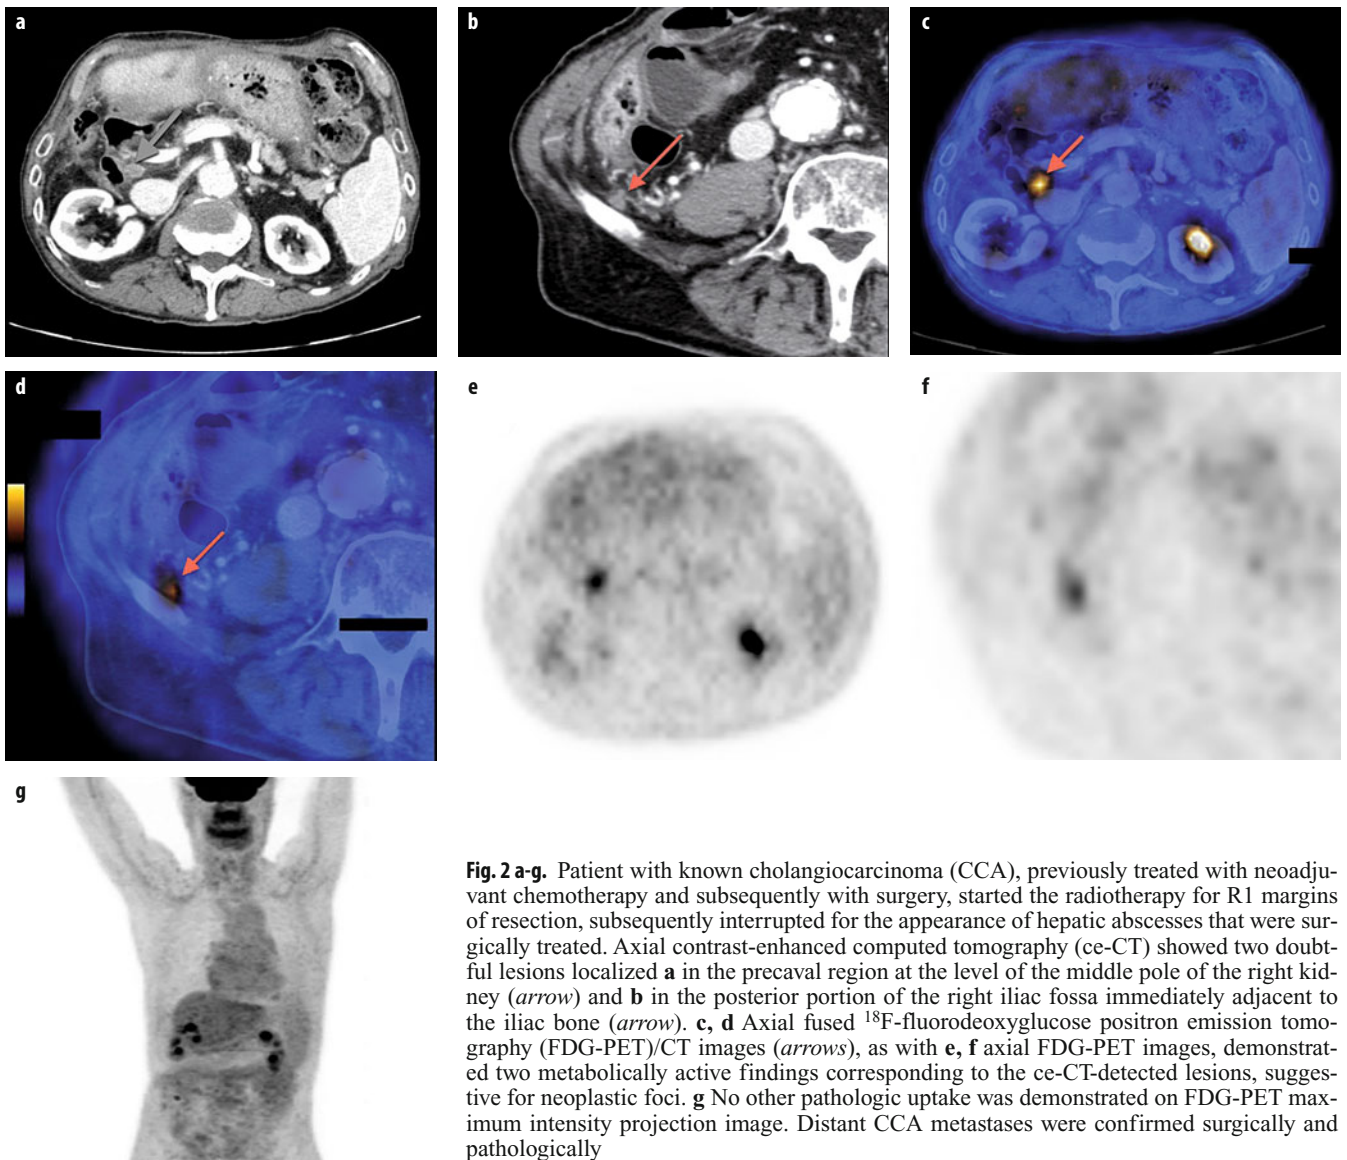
a-g. Patient with known cholangiocarcinoma (CCA), previously treated with neoadjuvant chemotherapy and subsequently with surgery, started the radiotherapy for R1 margins of resection, subsequently interrupted for the appearance of hepatic abscesses that were surgically treated. Axial contrast-enhanced computed tomography (ce-CT) showed two doubtful lesions localized a in the precaval region at the level of the middle pole of the right kidney (*arrow*) and b in the posterior portion of the right iliac fossa immediately adjacent to the iliac bone (*arrow*). c, d Axial fused ^{18}F -fluorodeoxyglucose positron emission tomography (FDG-PET)/CT images (*arrows*), as with e, f axial FDG-PET images, demonstrated two metabolically active findings corresponding to the ce-CT-detected lesions, suggestive for neoplastic foci. g No other pathologic uptake was demonstrated on FDG-PET maximum intensity projection image. Distant CCA metastases were confirmed surgically and pathologically
